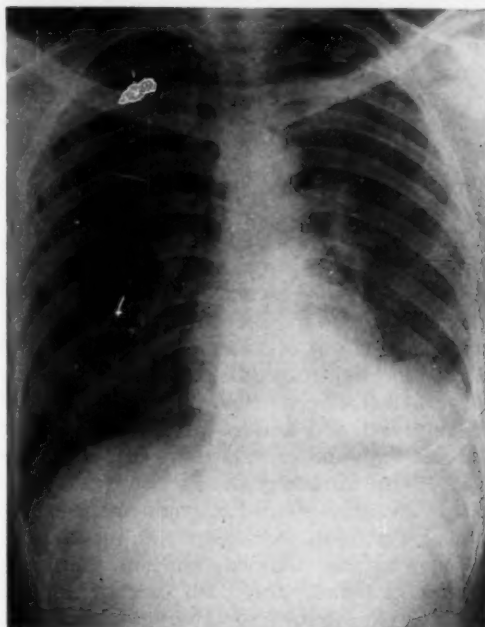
Chest roentgenogram shows tuberculosis involving the left upper lobe. There is an intrapulmonary effusion on the left. Note the lateral shift of the apex of the curve.
